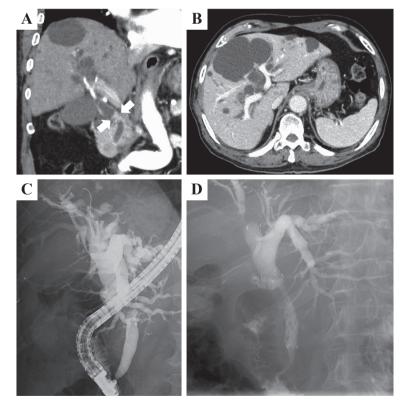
Computed tomography and endoscopic retrograde cholangiography images. A: Contrast-enhanced computed tomography image at the time of diagnosis of cholangiocarcinoma. Coronal image shows irregular wall thickening with contrast effect in the middle common bile duct (arrow). B: Axial image showing multiple hepatic cysts in both lobes of the liver, accompanied by intrahepatic bile ducts dilatation due to common bile duct obstruction. C: Endoscopic retrograde cholangiography showed stenosis of the middle common bile duct. D: Double uncovered self-expandable metallic stents (Niti-S Large Cell D-type 10mm×100mm) placed above the papilla by the partial stent-in-stent method.
